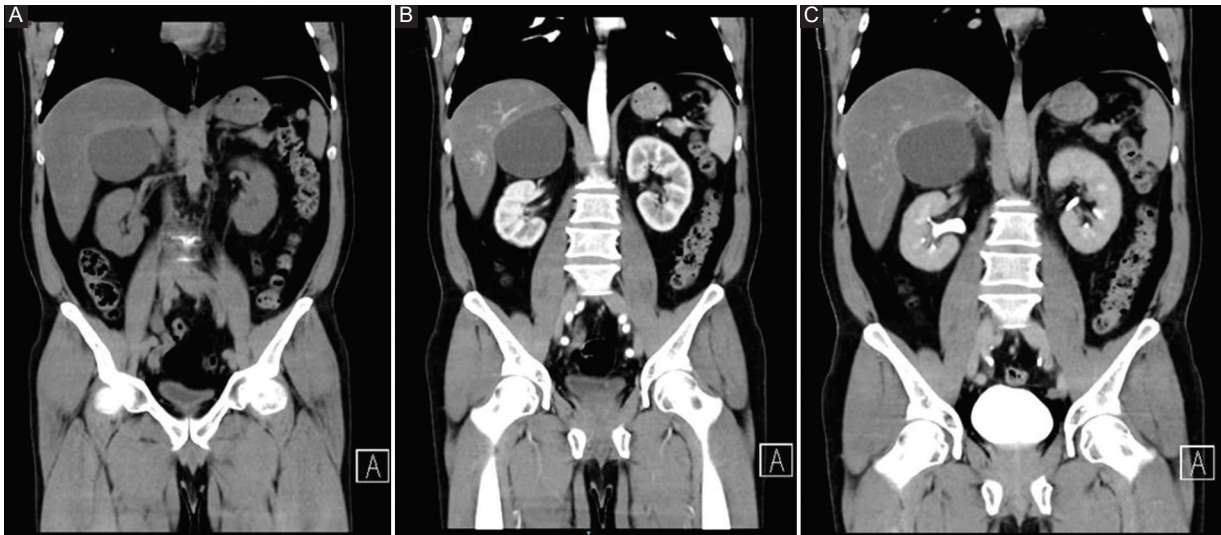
Computed tomography. A: Coronal section without contrast. B: Coronal section with intravenous iodinated contrast; no enhancement is observed. C: Coronal section at elimination phase.
